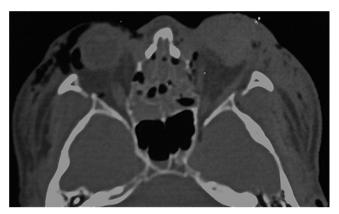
Axial CT scan showing multiple fractures and bone fragments affecting both orbits in a 57-year-old man with associated LeFort I fracture, frontal contusions, and a burst eye that required surgical extraction of the ocular globe.
